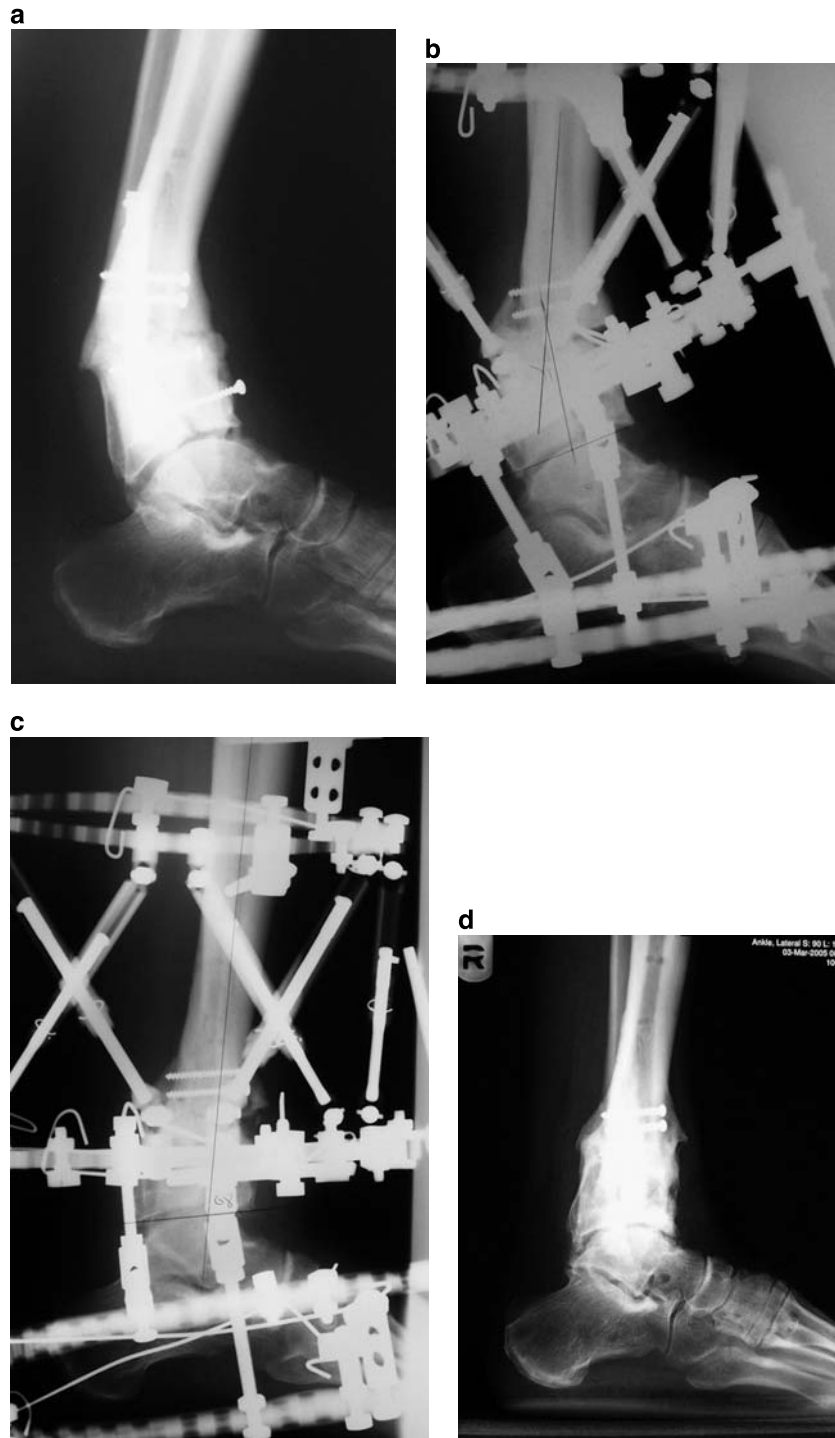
a Lateral x-ray showing a recurvatum deformity of the distal tibia with equinus contracture of the ankle. b Postoperative lateral x-ray showing a frame with potential for correction of the supramalleolar deformity and the ankle contracture. c Lateral x-ray 6 weeks later showing the correction. d Lateral x-ray 1 year later
